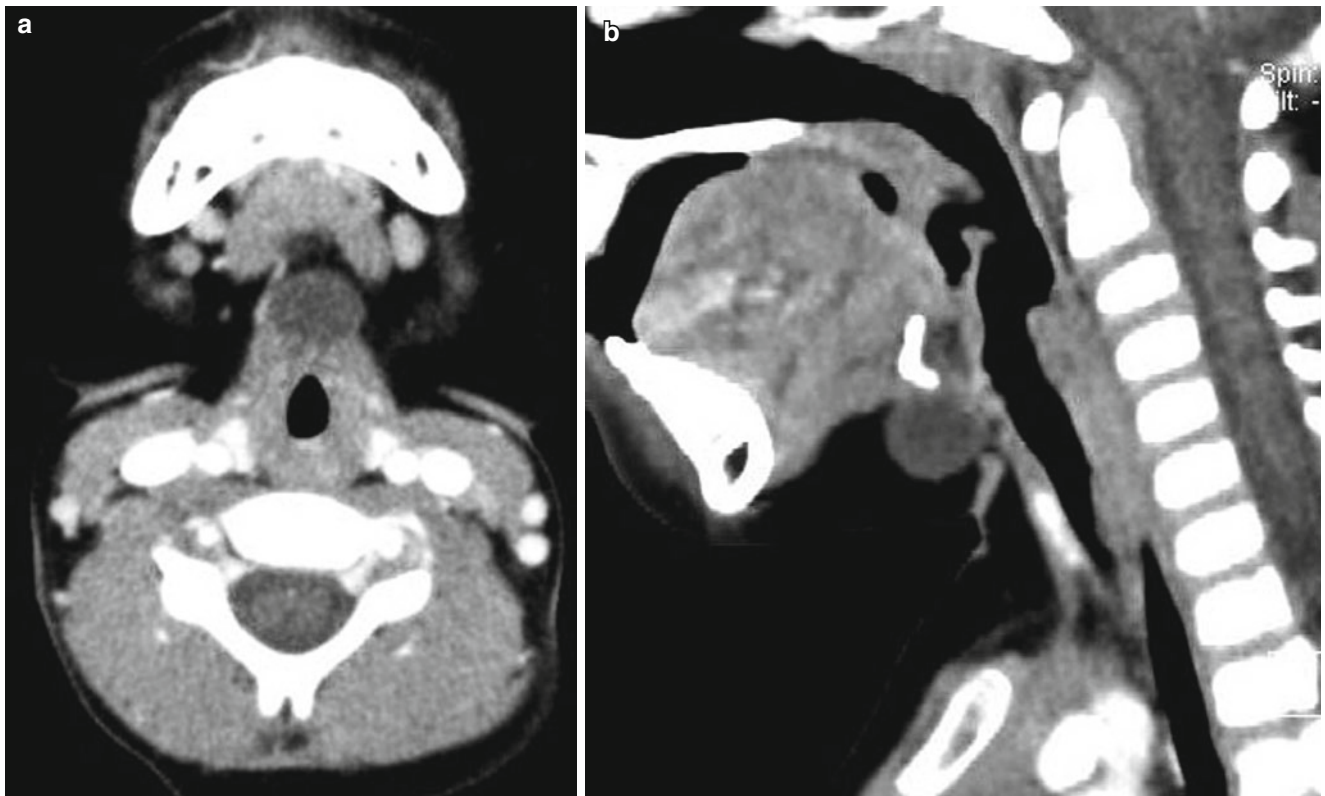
Thyroglossal duct cyst on the level of the hyoid bone in a 3-year-old boy. (a) Contrast-enhanced axial CT scan shows a round midline cyst in the submental space. (b) Sagittal reformatted CT scan shows a well-defined unilocular, thin-walled cyst abutting the hyoid bone
